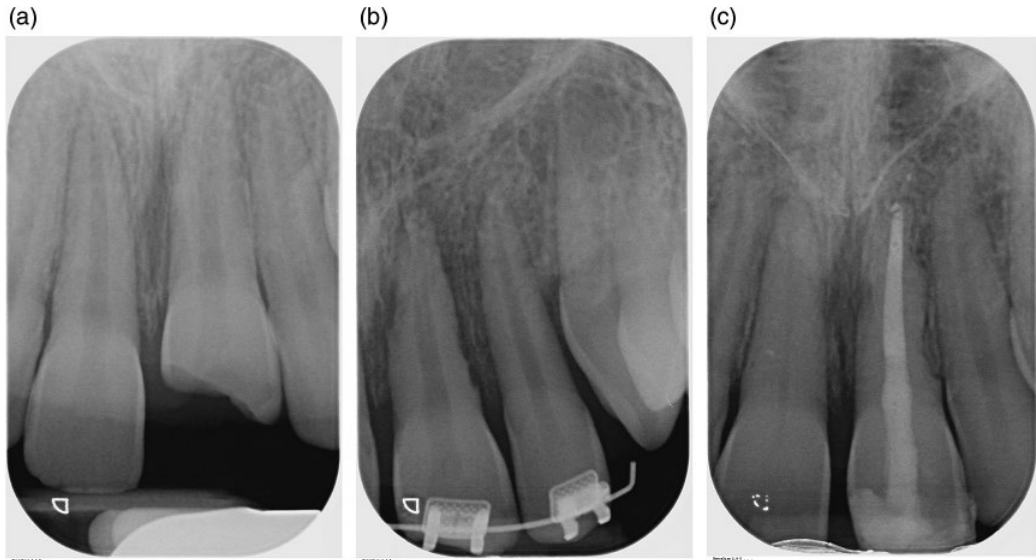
Dental trauma with external inflammatory resorption. (a) Periapical radiograph of maxillary central incisor teeth following a traumatic dental injury in which tooth 21 was severely intruded. (b) Within one week tooth 21 had undergone external inflammatory resorption with the development of excavations on the root surface of the tooth and associated radiolucencies in the adjacent bone. The entire root length, including the apical third, was involved. (c) Periapical radiograph of tooth 22 one year after the injury demonstrates resolution of the apical periodontitis and cessation of the resorptive process, although the shape of the root surface has been permanently altered.
